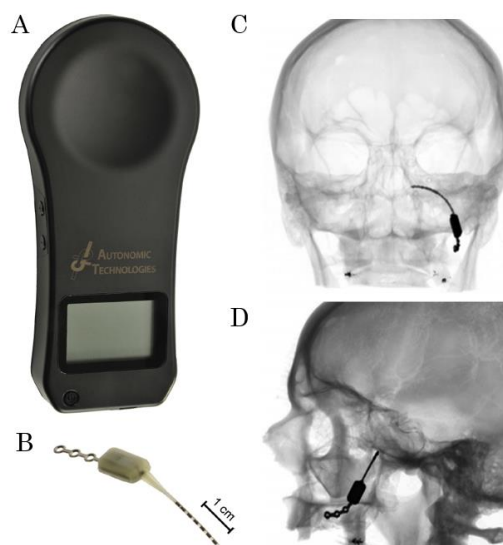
The sphenopalatine ganglion stimulation system remote control (A) and microstimulator (B). The device is depicted on digitally reconstructed coronal (C) and sagittal (D) radiographs with inserted models.⁸⁵ Reproduced with permission from Elsevier.
